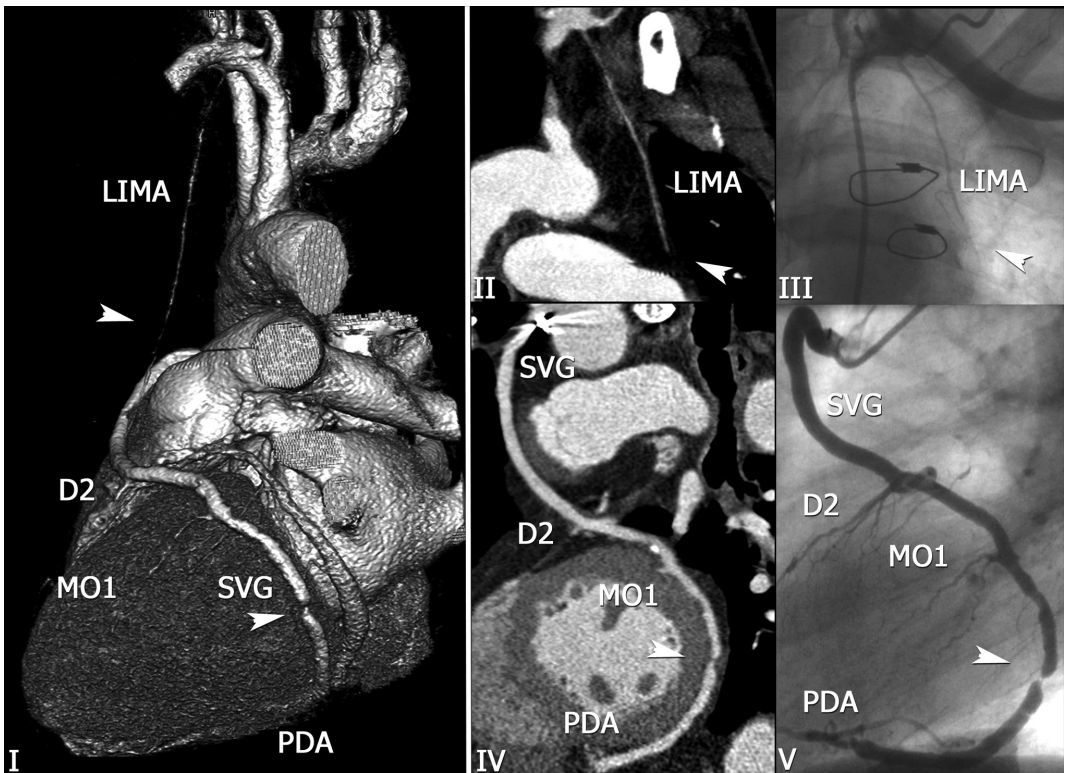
Volume-rendered reconstruction (I) and curved multiplanar reformations (II,IV) of a CT scan and corresponding conventional angiography (III, V), which show an occluded left internal mammary artery (LIMA, arrow in I,II,III) and obstructed vein graft (SVG). The venous graft has three coronary anastomoses: second diagonal branch (D2), first marginal branch (MO1), posterior descending artery (PDA), of which the terminal segment is significantly stenosed (arrow I, IV, V).
